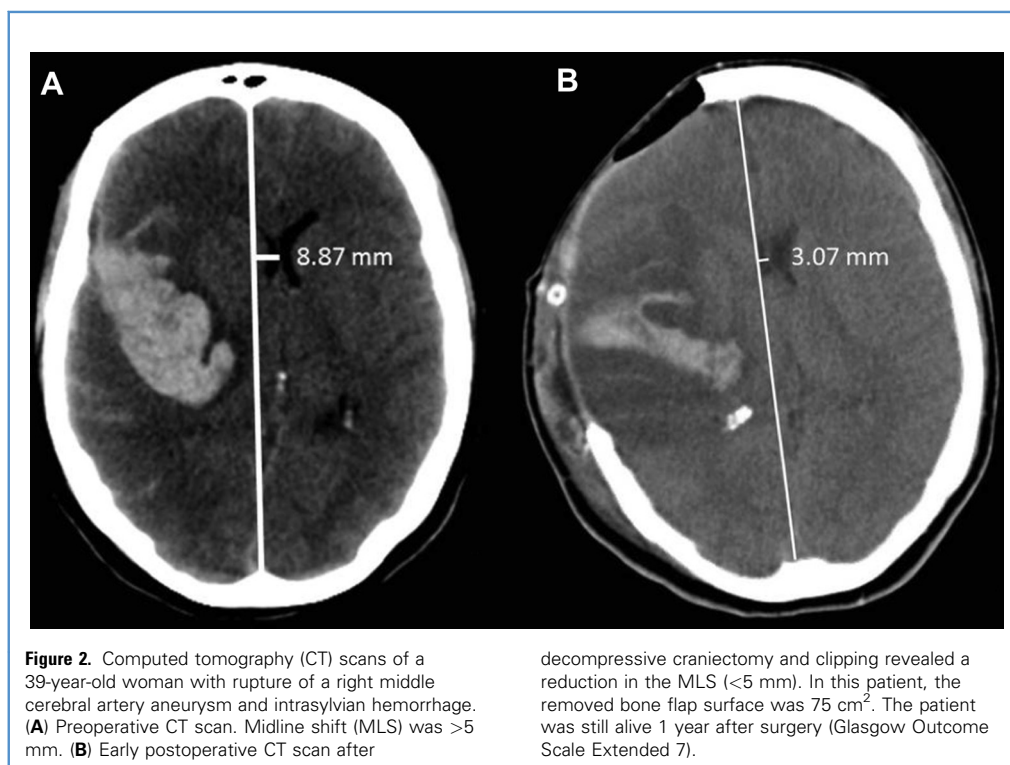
Computed tomography (CT) scans of a 39-year-old woman with rupture of a right middle cerebral artery aneurysm and intrasylvian hemorrhage. (A) Preoperative CT scan. Midline shift (MLS) was >5 mm. (B) Early postoperative CT scan after
